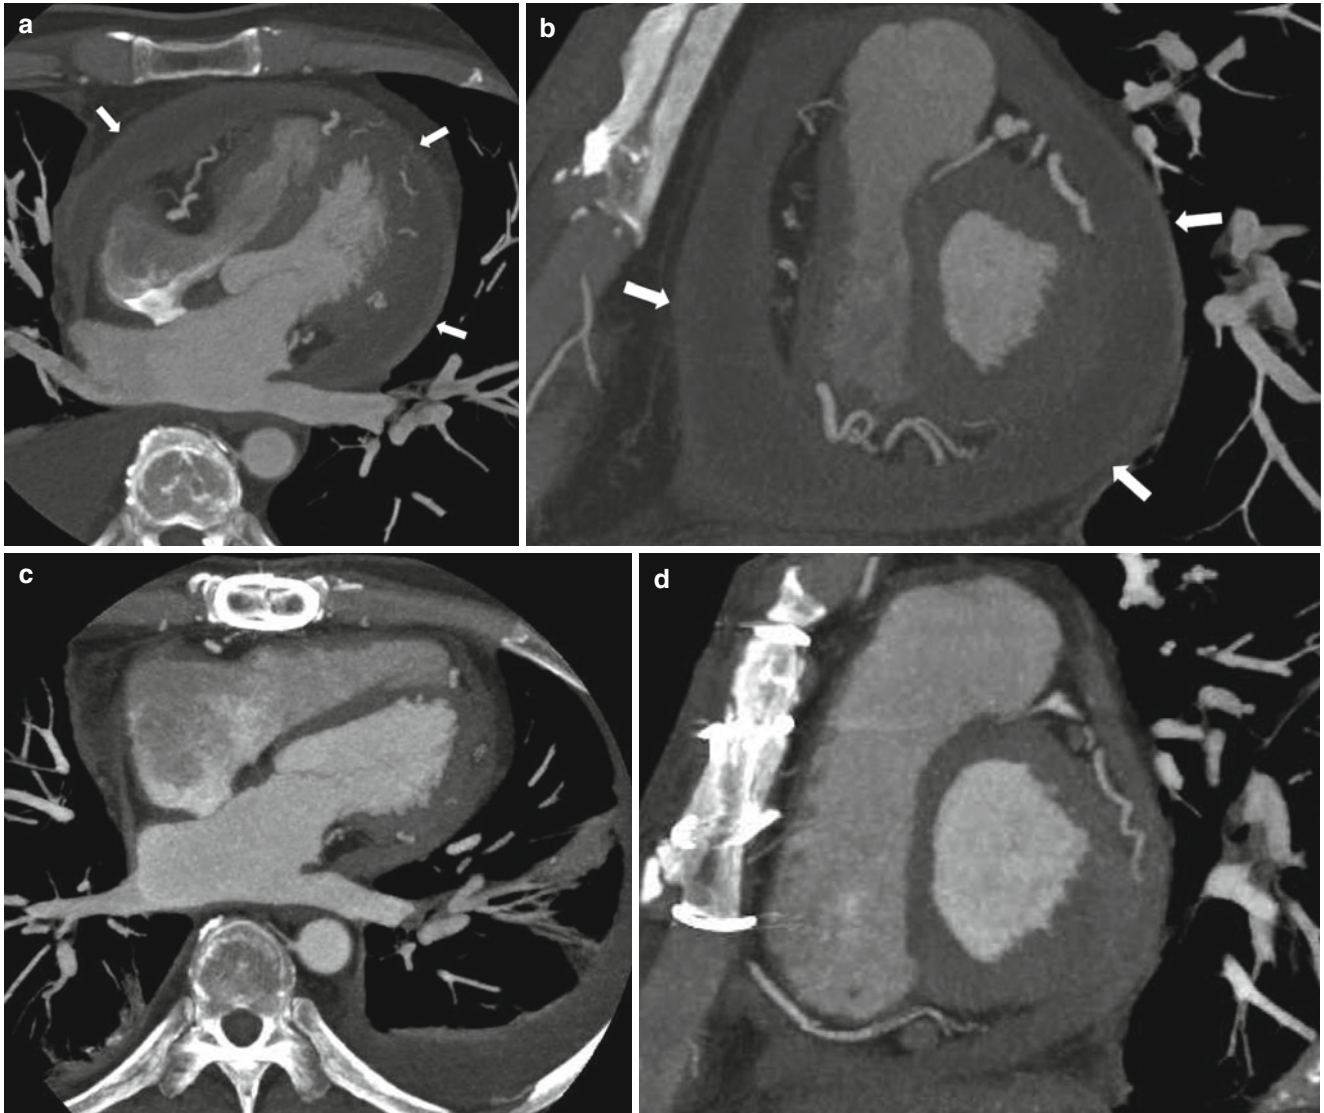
Effusive constrictive pericarditis. Axial (a) and short-axis (b) images of initial cardiac CT show pericardial effusion, thickened and enhanced pericardium (arrows), narrowed both ventricular shape, and inverted interventricular septum. After pericardiectomy pericardial
